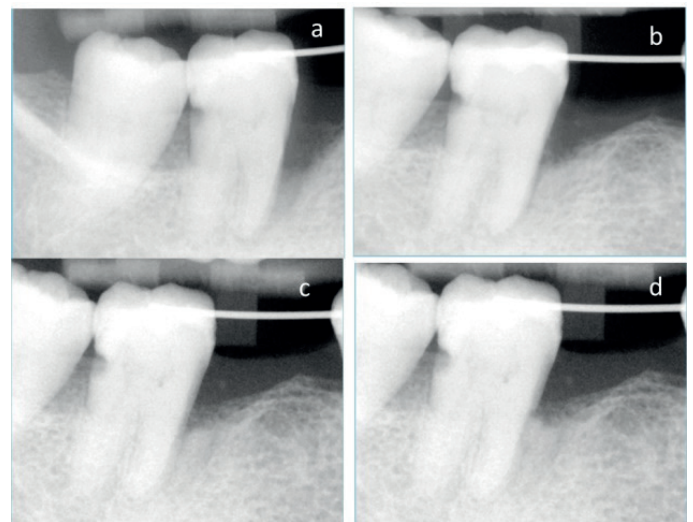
Control site radiographic evaluation at baseline (a), three months (b), six months (c) and 9 months (d).
